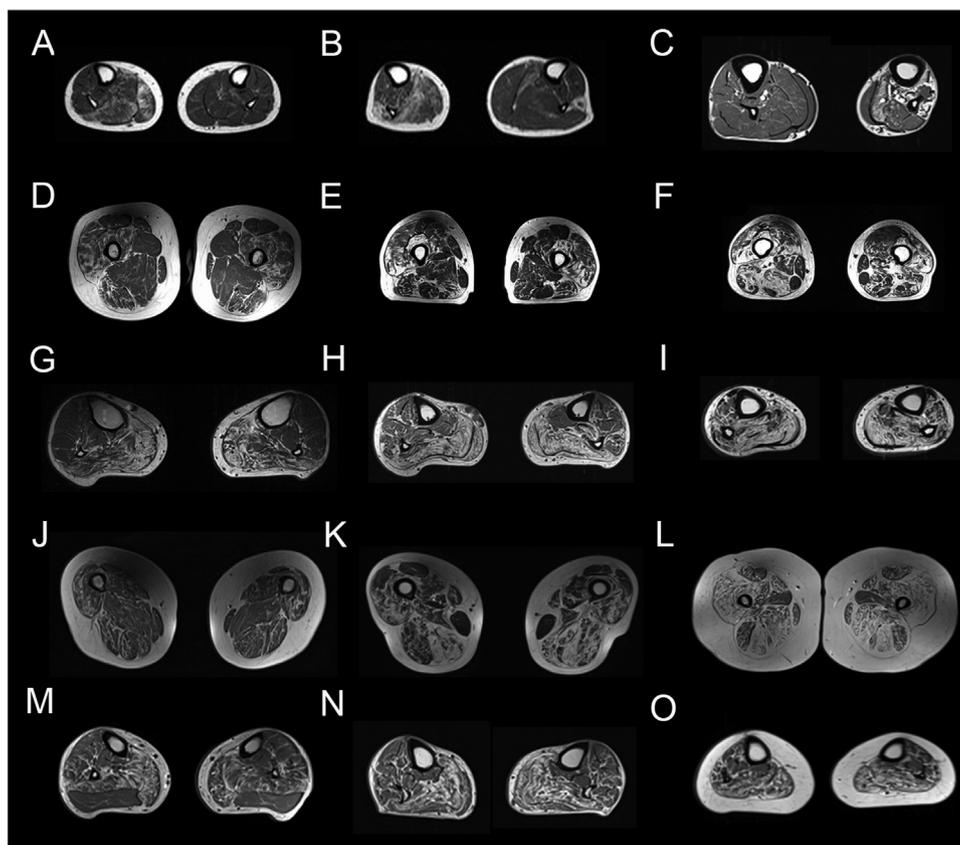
Common features on T1w imaging of patients with dHMNs. T1w imaging showing characteristic features common to patients with dHMNs. A, B and C, show asymmetric involvement of the muscles of the lower legs. Distal to proximal gradient of fat replacement was observed as show in D to F: D shows an MRI of the thigh at proximal level, E at medium level and, F at distal level. This gradient was also observed in legs, as show in G to I: G shows an MRI of the leg at proximal level, H at medium level and, I at distal level. Examples of the progression of the fat replacement from reticulate pattern in the thigh (J) and leg (M) towards fat islands (K-L and N-O) are also shown.
